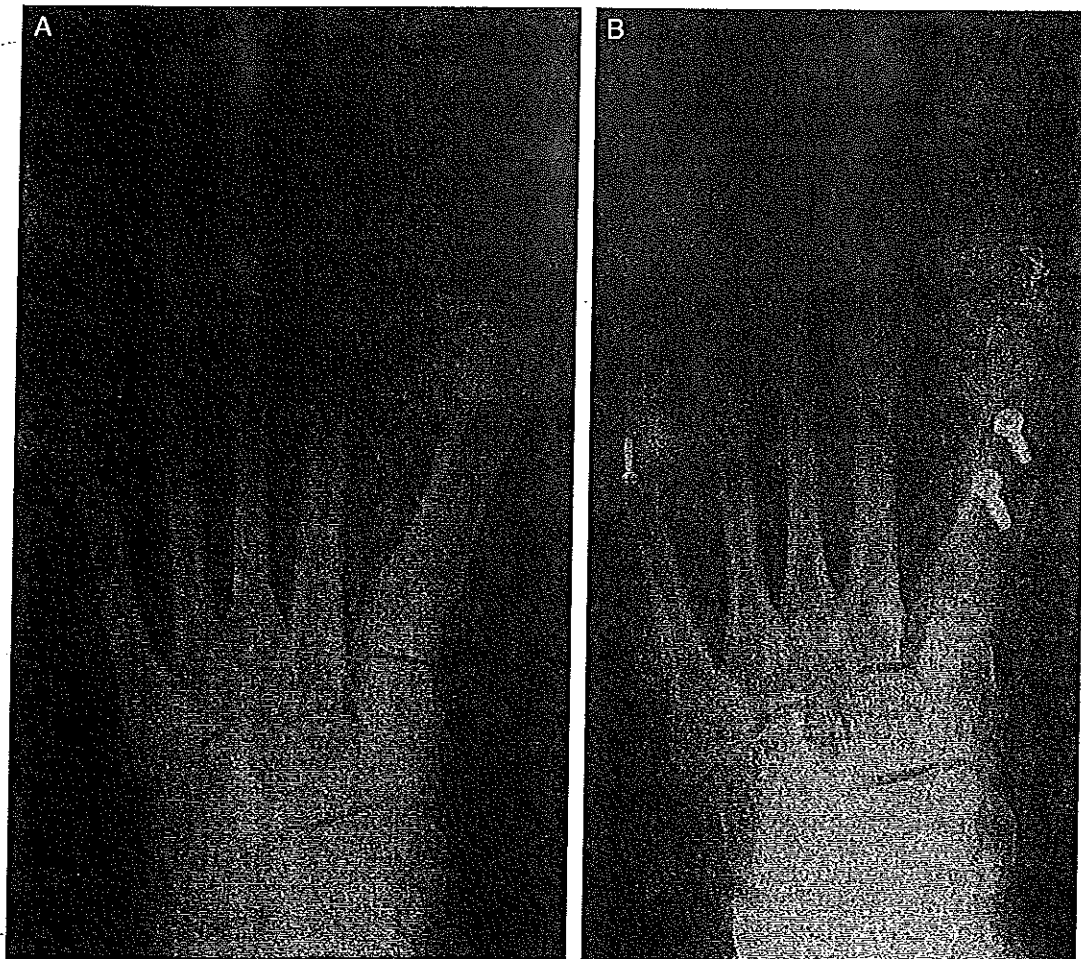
AP weight-bearing radiographs depict correction of hallux valgus deformity attained with the inverted Z-scarf osteotomy construct in this series. (A) Preoperative radiograph. (B) Postoperative radiograph. Note the rotated position of the capital fragment/superior arm to maintain cortical apposition of the metatarsal.
